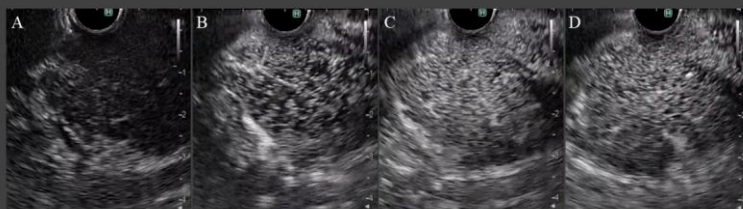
A) Pre-contrast, B) 20 seconds after contrast injection, C) 40 seconds after contrast injection, D) 60 seconds after contrast injection. Contrast-enhanced harmonic endoscopic ultrasonography using an ultrasound contrast agent (Sonazoid®; Daiichi-Sankyo, Tokyo, Japan) demonstrated homogeneous enhancement of the pancreatic parenchyma from approximately 20 seconds after contrast injection, which persisted beyond 60 seconds after injection.
